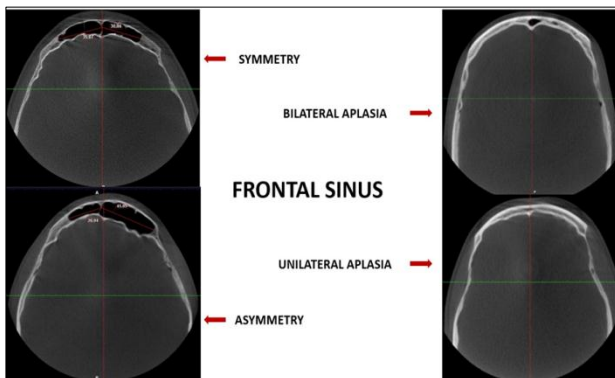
Various patterns of frontal sinus as seen in CBCT images
